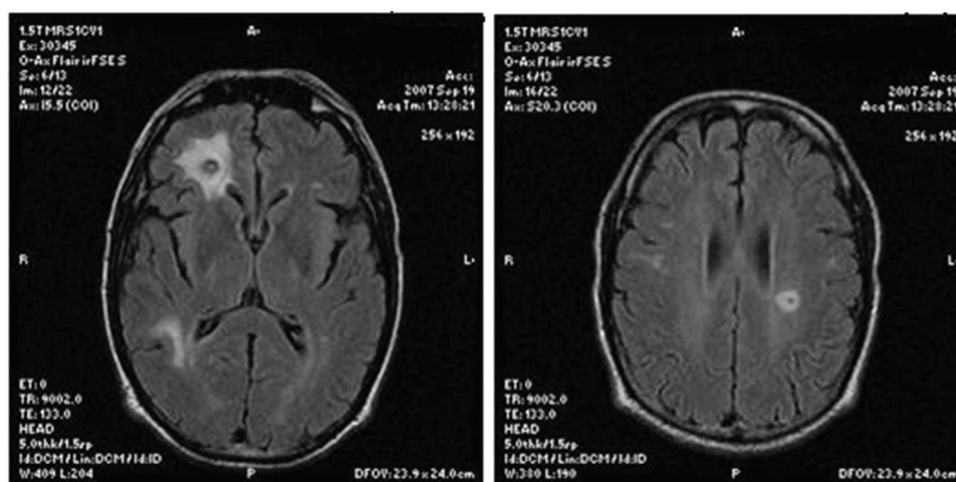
Head MRI, with multiple abscesses of small dimensions (the biggest with 5 mm) in the white matter (frontal and temporal on the right hemisphere and parietal and posterior frontal on the left hemisphere). Perilesional vasogenic oedema of the white matter, without deformation of the sulci and ventricular contour.
